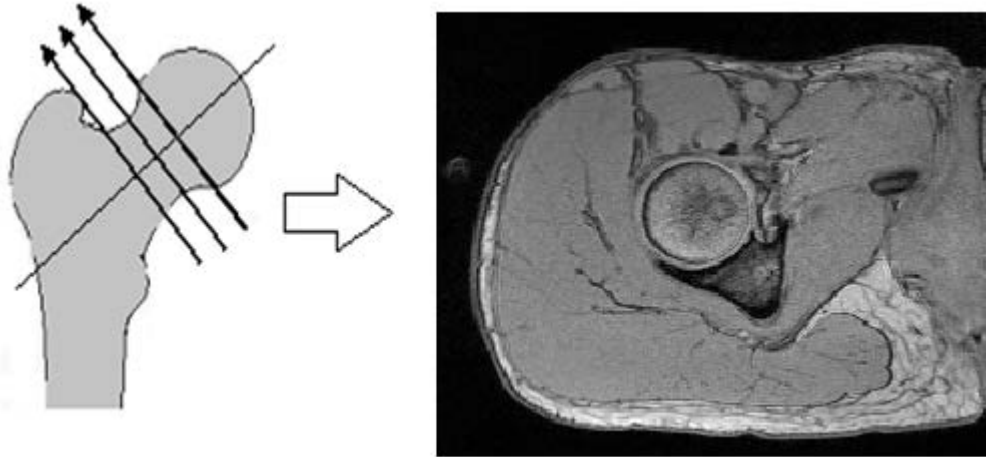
Imaging plan Orientation setup during the MR image acquisition process*
